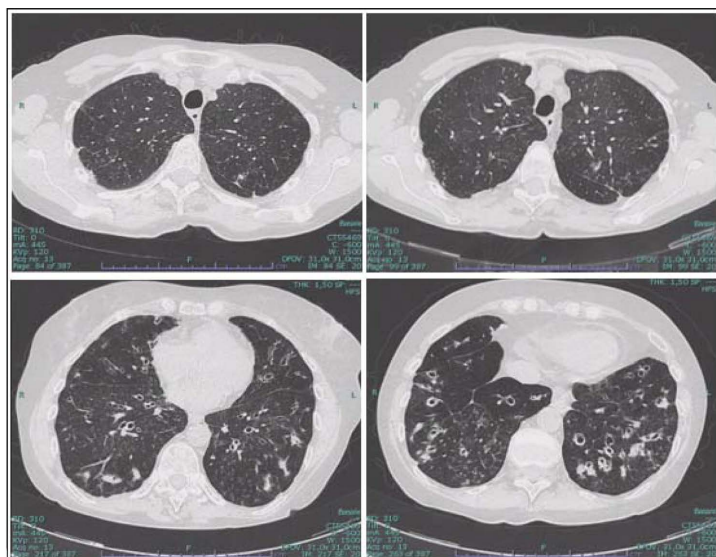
Chest CT scan shows infectious signs and known bronchiectasis.
